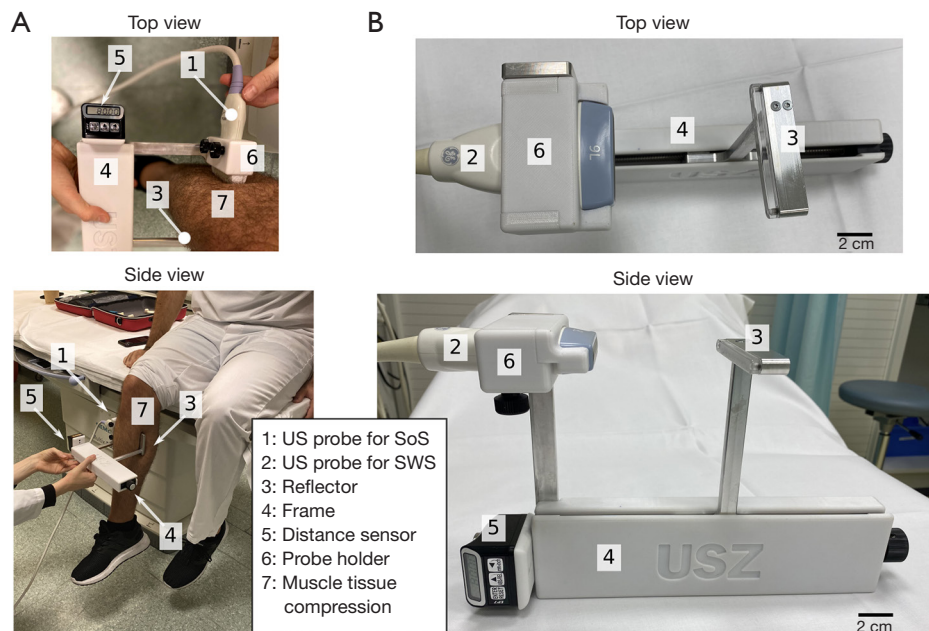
Experimental setup and measurement device. (A) Experimental setup used for shear-wave speed (SWS) and speed of sound (SoS) measurements. During the examination, volunteers are in a sitting position, with the calf muscle relaxed. Reproducible tissue compression is applied with the ultrasound (US) probe and the reflector. (B) Measurement frame with the reflector and the 3D printed transducer holder attached to it. It incorporates a distance sensor.
